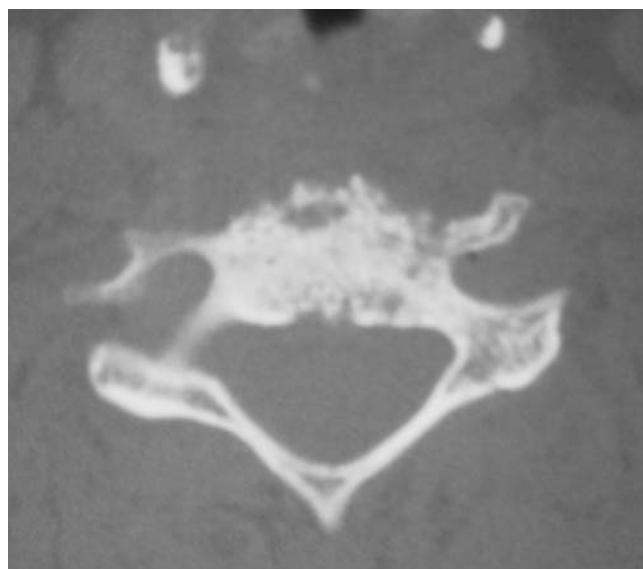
Case 1. CT scan of C4 shows sclerotic lesion of the vertebral body.
